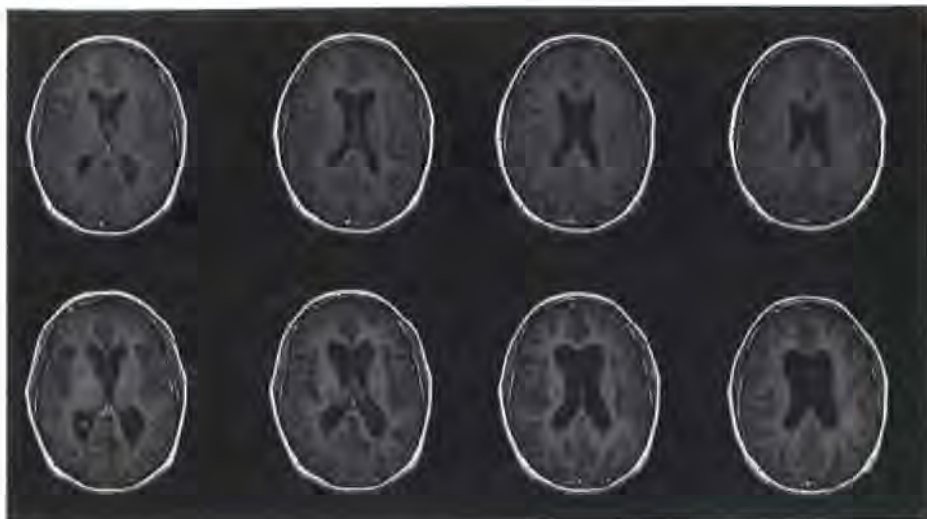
Serial T₁-weighted MRI over 18 months in a patient with secondary progressive multiple sclerosis showing striking development of atrophy. The top row shows baseline scans at four different levels in the brain and the bottom row shows the scans 18 months later at the corresponding levels.
